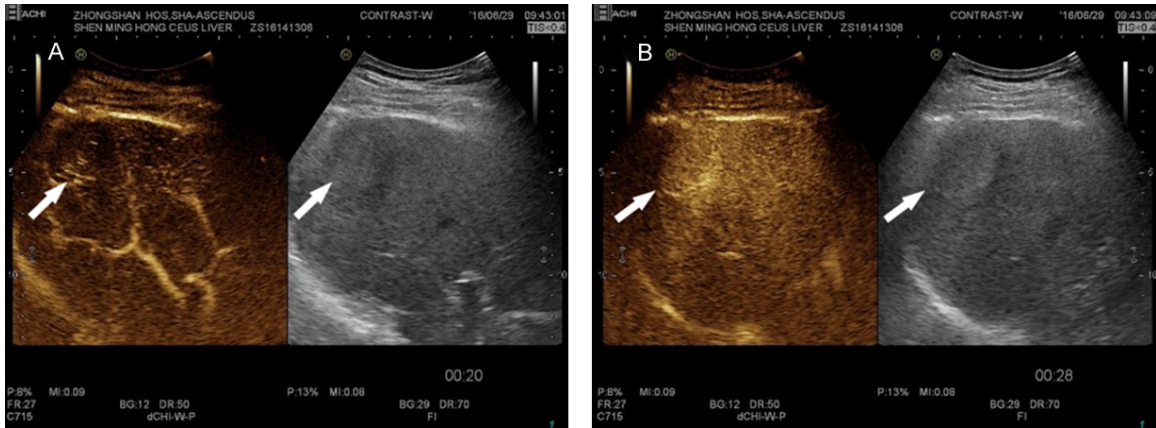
Contrast-enhanced ultrasound. After using SonoVue, the entity in the right liver was enhanced at 20 s (A) and reached a peak at 28 s (B).
